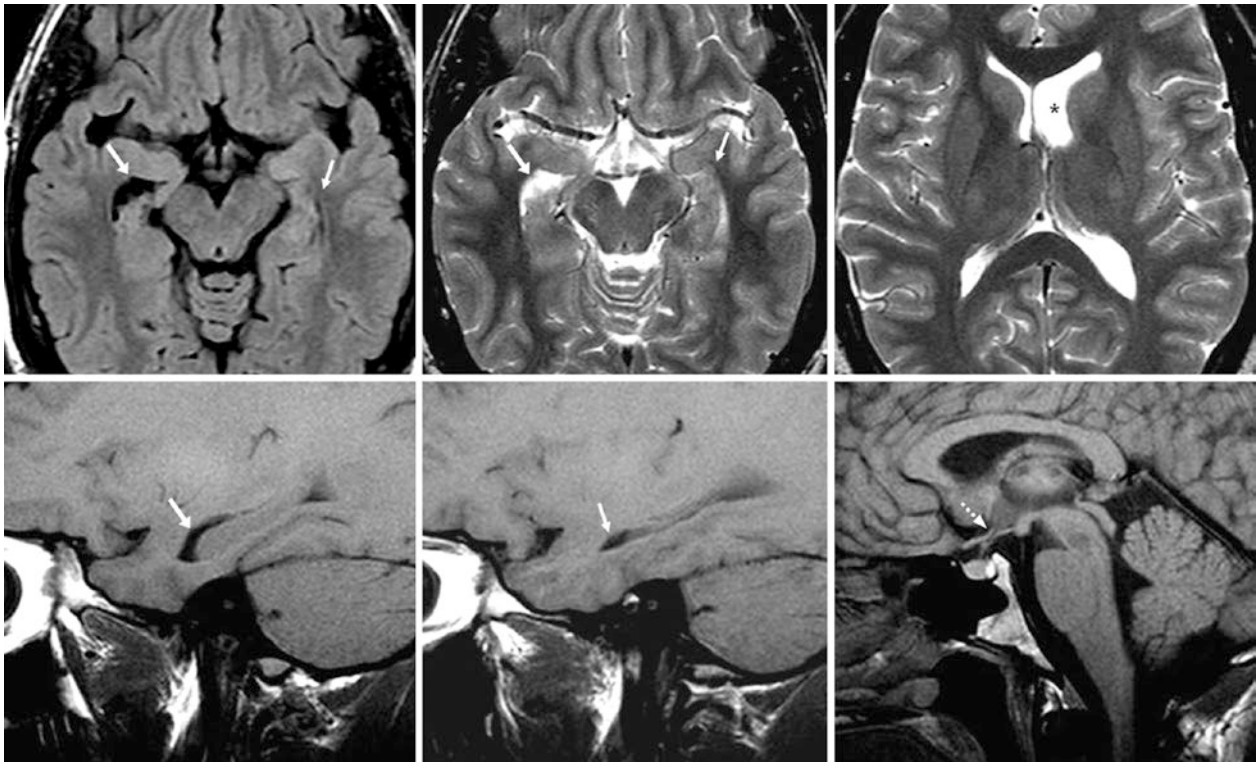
An 18 year old with asymmetric prominence of the right temporal horn (*arrows*) on FLAIR (*top left*) and T2WI (*top middle*) when compared with the left one (*thin arrows*). The left lateral ventricle's frontal horn (*) and body appear larger on higher images (*top right*); this is
